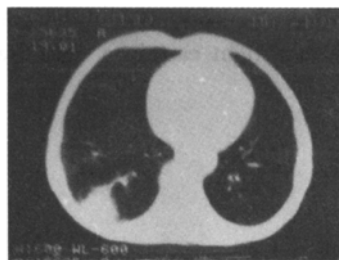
CT scan confirmed the findings of RII.
